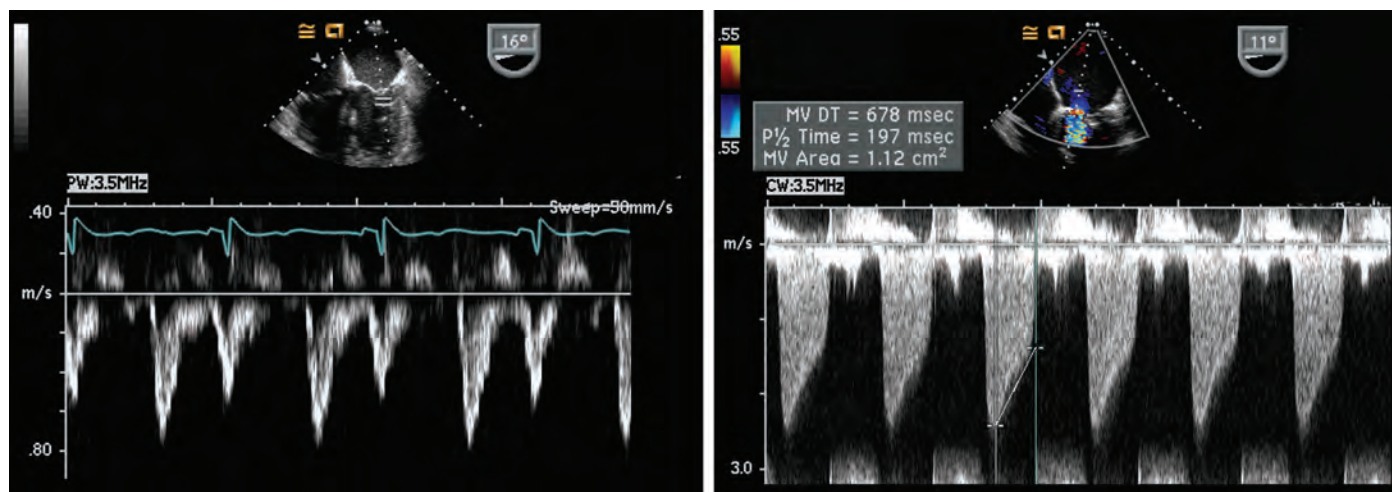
Transmittal Doppler spectrum. The panel on the left is the normal transmittal Doppler flow measured using pulsed-wave Doppler. A clean envelope is visualized with E-wave velocity greater than the A-wave velocity. Both waves have velocities less than 1 m/sec with a normal deceleration time. The panel on the right visualizes the transmittal flow in the presence of mitral stenosis. Because of the high gradient, continuous-wave Doppler was used. High-velocity gradients may be appreciated, and a longer pressure half-time is consistent with significant mitral stenosis.
